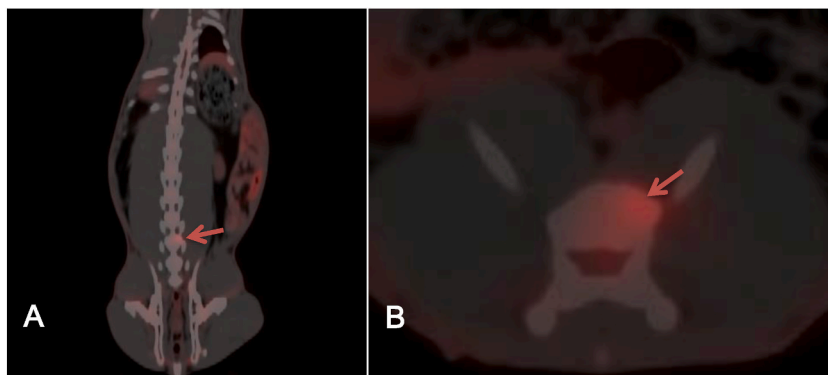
7 days after planting, PET-CT image of L5 vertebra VX2 tumor model, radionuclide concentration in the vertebral body (red arrow area). A: coronal view; B: axial view. (For interpretation of the references to colour in this figure legend, the reader is referred to the Web version of this article.)
